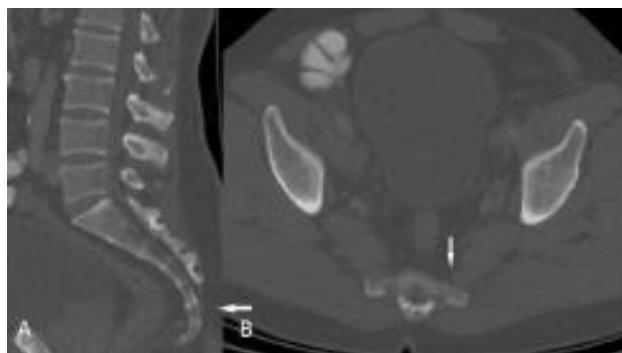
Computed tomography (CT) revealed no significant finding except degenerative changes in the sacroiliac region (A; sagittal plane, B; transaxial plane, arrows).
